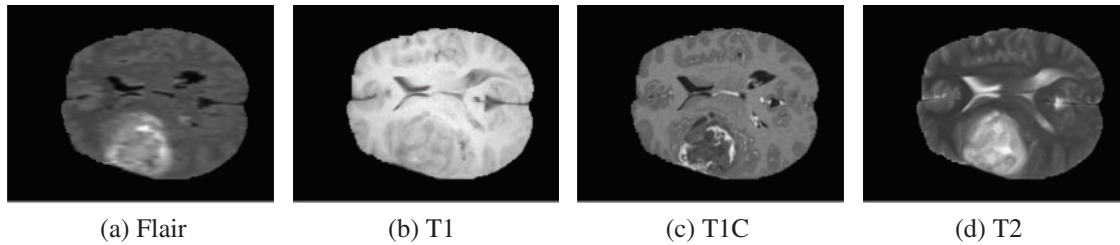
Sample test images of various MRI modalities collected from BRATS2015
